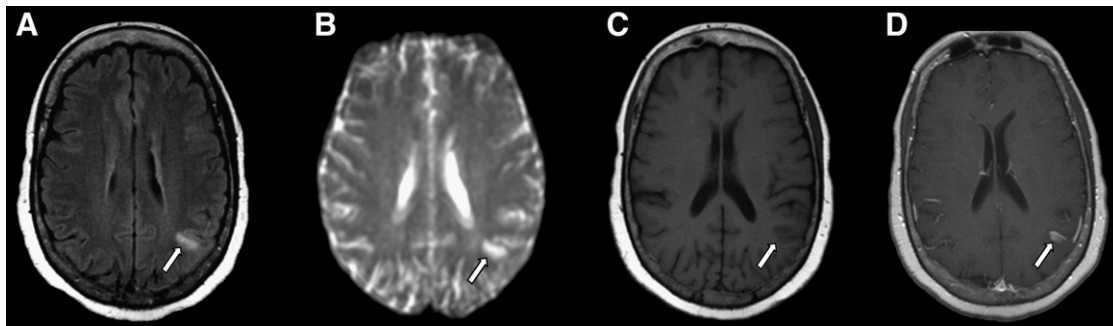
Parietal metastasis sequence. A: Axial FLAIR image with hyperintensity in the left parietal lobe (white arrow). B: DWI image with hyperintensity in the left parietal lobe (white arrow). C: Axial T1weighted image with mild hypointensity in the left parietal lobe (white arrow). D: Post-contrast axial T1weighted image with a small enhancing area in the left parietal lobe (white arrow).
